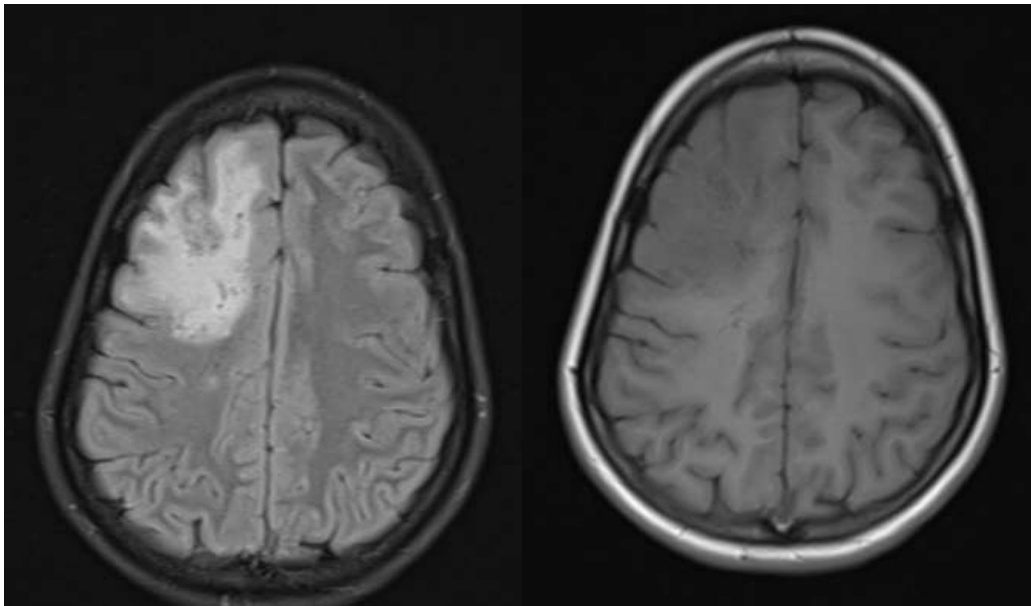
T1 weighted images and FLAIR images of the patient: On flair heterogenous hyperintense lesion noted in right frontal lobe which is hypointense on TIWI
